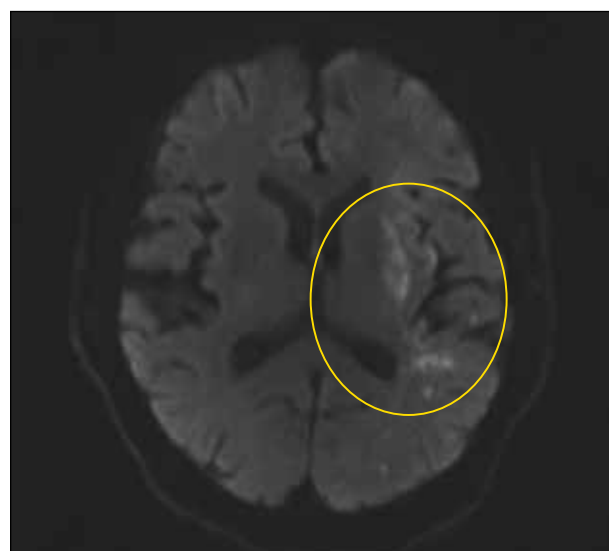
MRI axial diffusion image. Areas of increased signal intensity indicate acute stroke. The encircled area indicates the area of embolic stroke.
